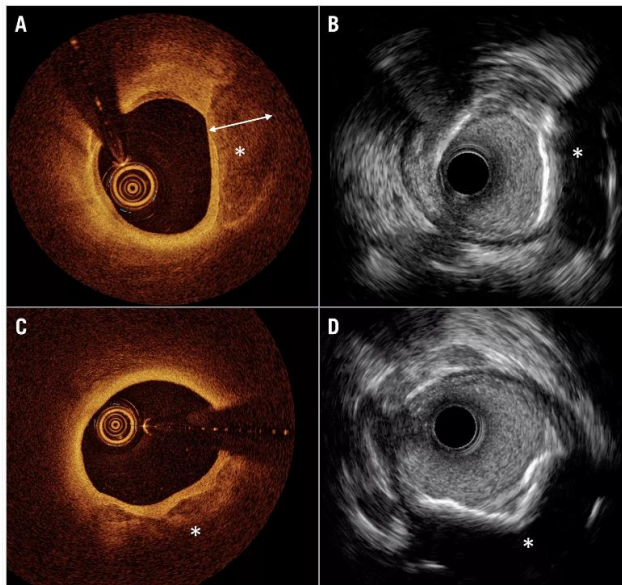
Comparison of coronary calcium imaging by optical coherence tomography and high-definition intravascular ultrasound. A) Optical coherence tomography (OCT) shows superficial calcium extending to the medial layer (*). The calcium (*), where thickness can be measured due to the optical properties of light penetration through the calcium crystal. B) Co-registered image on high-definition intravascular ultrasound (HD-IVUS) does not allow measurement of calcium thickness. C) OCT shows superficial calcium extending to the medial layer (*), where thickness cannot be measured due to the limited penetration depth of light. D) Co-registered image on HD-IVUS does not allow measurement of calcium thickness.
